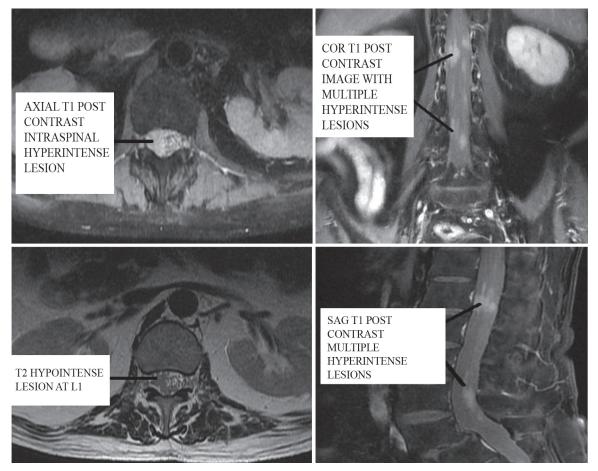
Plain & Post contrast MRI study showed multiple mildly enhancing oval lesions on the nerve roots in spinal canal mainly at L1 and L4 vertebral level
